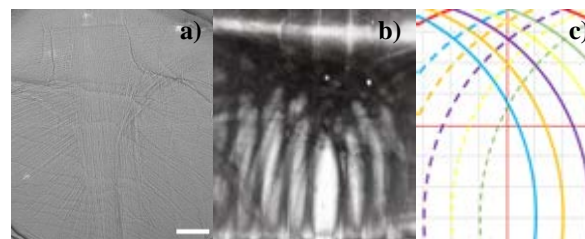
Resulting 3D scaffolds: SEM images (a), μ CT reconstruction (b) and the programmed alignment (c). Scale bar: 500 μ m.
